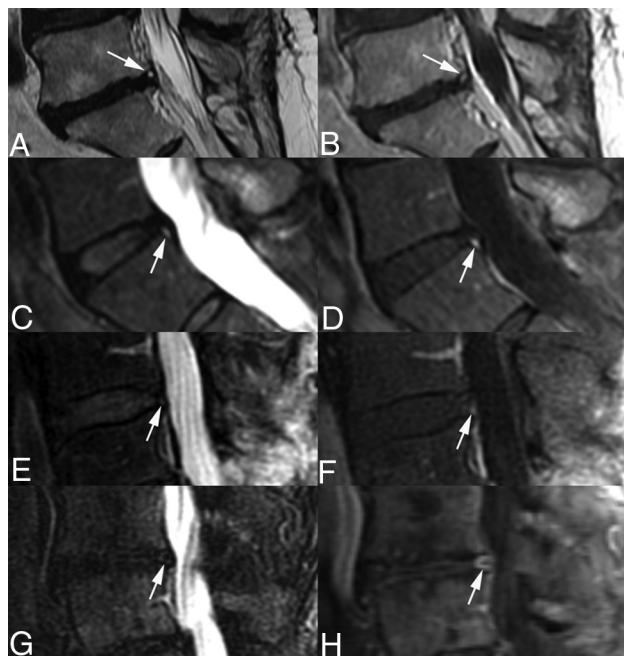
T2-weighted sequence grading of annular fissures detected on postcontrast T1-weighted imaging. A, Grade 4 annular fissure: annular fissure signal has high signal intensity (arrow) with signal that is greater than that of adjacent spinal fluid, consistent with an HIZ. B, Enhancement in the Grade 4 annular fissure (arrow). C, Grade 3 annular fissure: annular fissure signal has high signal intensity (arrow) with signal that is less than that of the adjacent spinal fluid, consistent with an HIZ. D, Enhancement in the Grade 3 annular fissure (arrow). E, Grade 2 annular fissure: annular fissure signal is focally abnormal but with mixed intermediate-to-low signal intensity (arrow) appearing close to the signal of the degenerative disc without a definite HIZ. F, Enhancement in the Grade 2 annular fissure (arrow). G, Grade 1 annular fissure: annular fissure signal is abnormal and has low signal intensity (arrow), appearing similar to the signal of other portions of the severely degenerative disc. H, Enhancement in the Grade 1 annular fissure (arrow).
